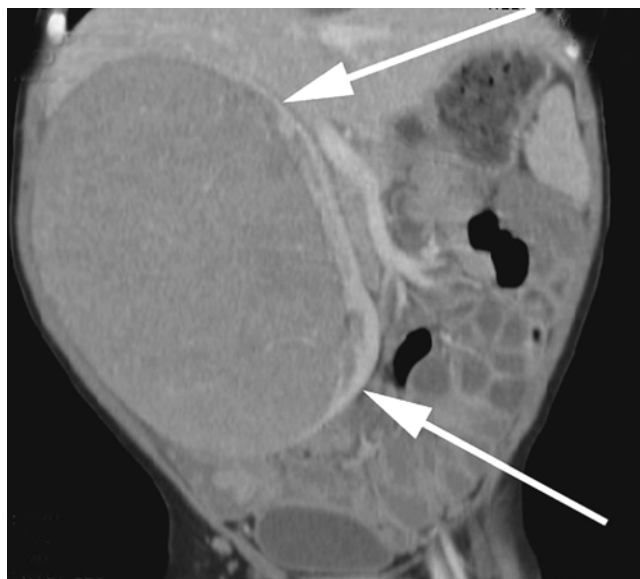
CT scan of a 6 month old infant with Wilms tumor which demonstrates in the coronal reformats the classic finding of intrarenal tumors; a margin of renal parenchyma enveloping the tumor (arrows)
